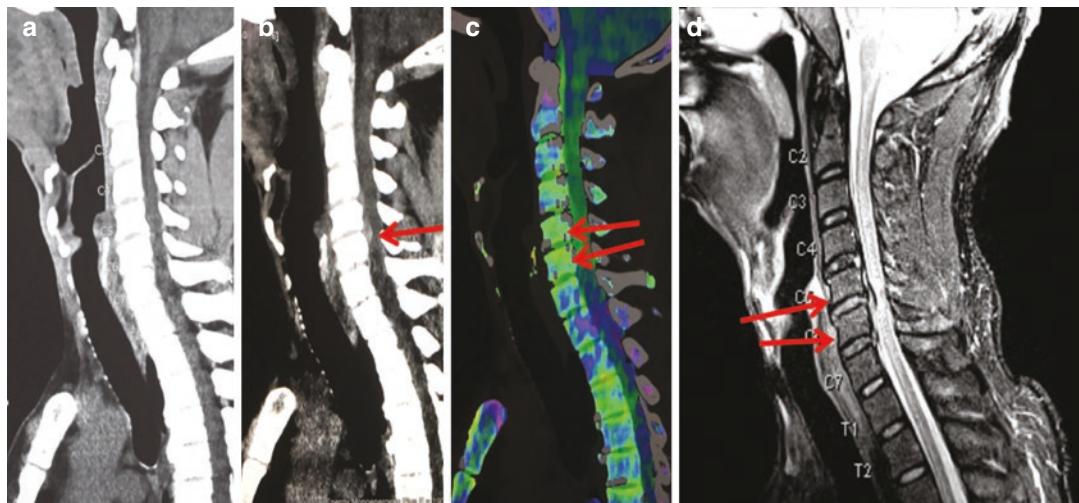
Monoenergetic sagittal cervical spine CT reformations acquired at (a) 120 kV and (b) 190 kV, the latter of which provides superior imaging details for identifying the epidural hematoma. Virtual non-calcium (VNCa) image (c) of the same patient shows associated
